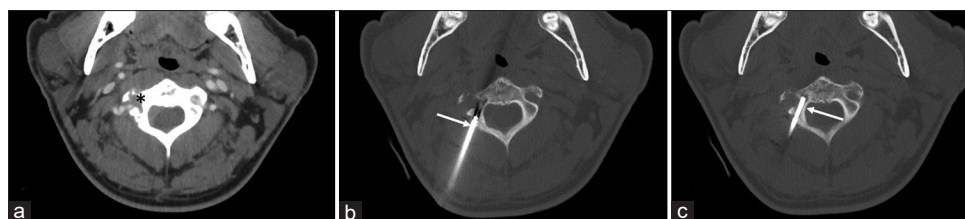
(a) Contrast enhanced axial pre-procedural CT showing the compression of the right vertebral artery by neoplastic tissue (asterisk). (b) the needle's progress halfway through the procedure as it moves toward its intended target, and (c) the needle successfully reaching and being positioned within the target lesion (arrow).
